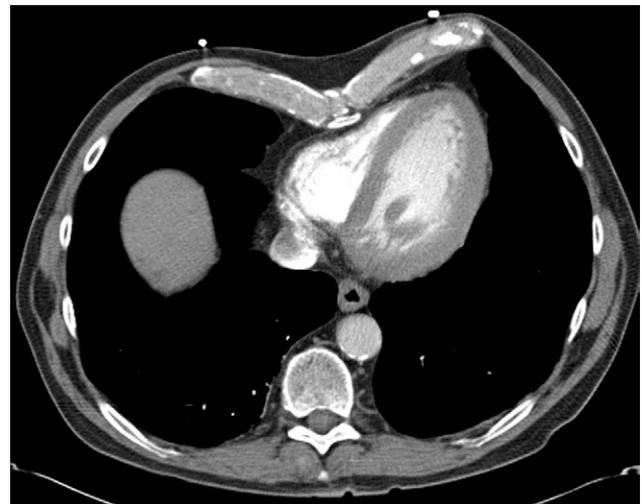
Computed tomographic scan showing pectus excavatum deformity impinging on the right ventricle of the heart.
